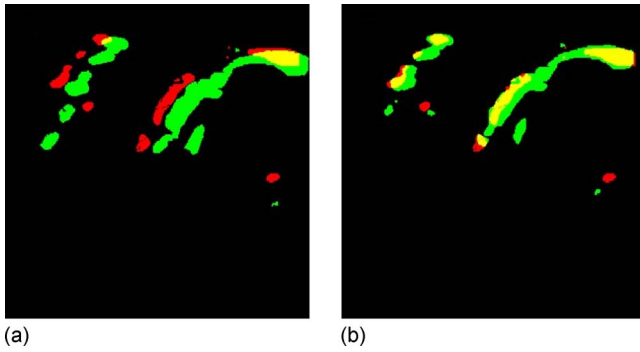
(a) Unregistered pair and (b) registered pair in a slice of 3D Doppler color image volumes with grayscale portion blacked out. Dark gray (red) was the color of blood flow under moderate breast compression, medium gray (green) under relaxed compression, and light gray (yellow) was the overlap region. Notice the increase in flow with relaxation and also the increase in the light gray (yellow) region with registration. The registration was performed on the grayscale portion of the image volume with colored pixels zeroed. Refer to Figs. 5 and 6.
